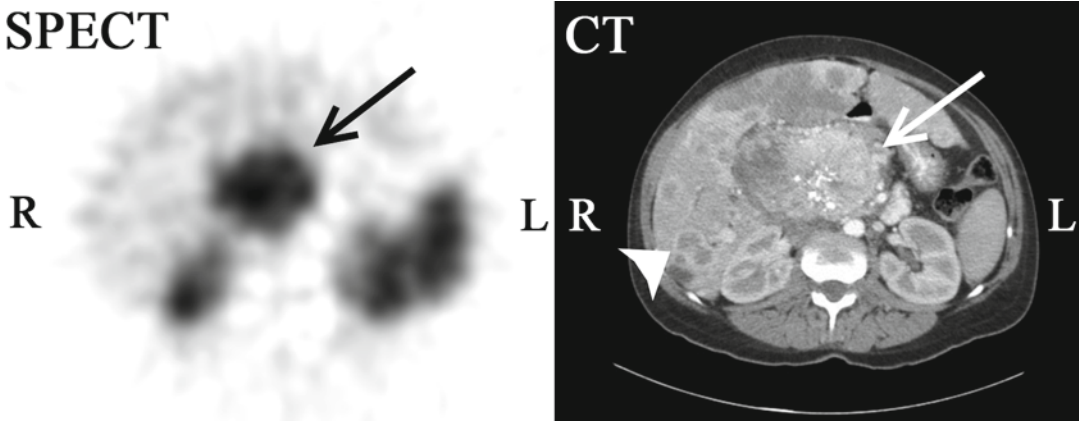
¹¹¹In-octreotide SPECT-CT scan of a 47-year-old female with a large abdominal mass. ¹¹¹In-octreotide, a somatostatin analogue labeled with indium-111 binds somatostatin receptors which are overexpressed in some neuroendocrine tumors (NETs). The study shows an abdominal rounded mass (*arrow*) with intense tracer uptake demonstrating a tumor expressing somatostatin
